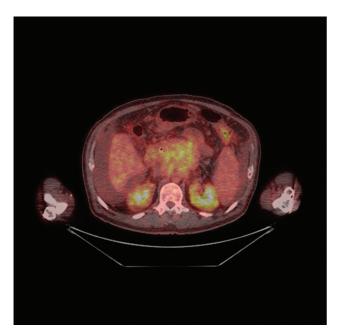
PET/CT (18FDG): expansive pancreatic lesion, with involvement of celiac and superior mesenteric arteries (SUV max: 3.3).
